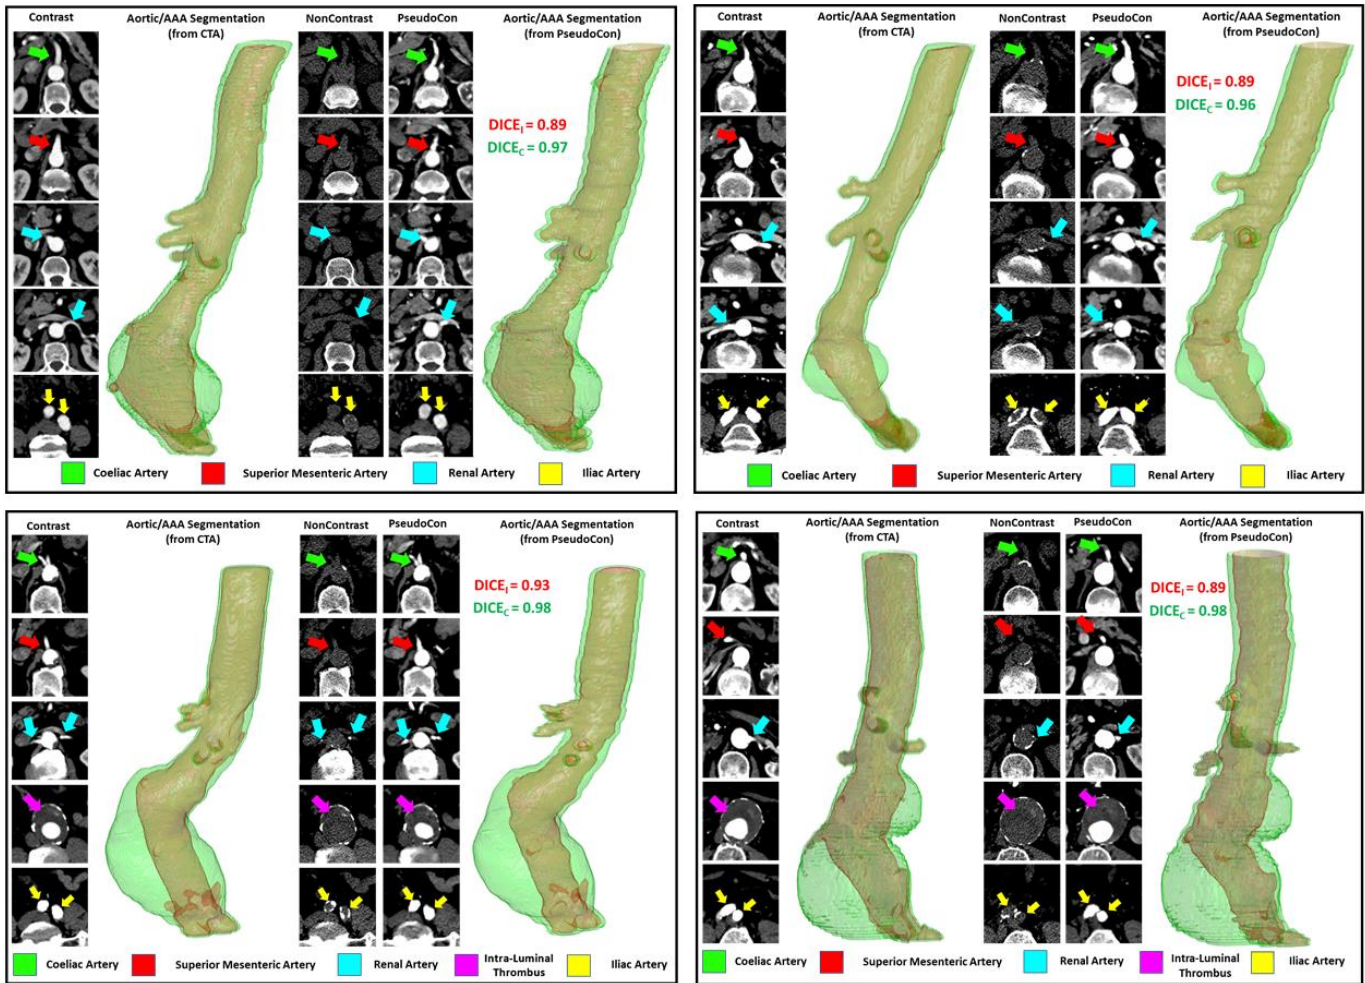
Pseudo-Contrast CT images are displayed alongside their respective Contrast and Non-Contrast CT Images for four patients. Arrows indicating the branch arteries (Celiac artery, Superior Mesenteric Artery, Renal arteries, and Iliac arteries) and the intraluminal thrombus are highlighted wherever visible. Aortic segmentations including the side branches are generated from both the CECT (gold standard) and the Pseudo-Contrast CT and DICE scores comparing the segmentations are displayed¹¹.
